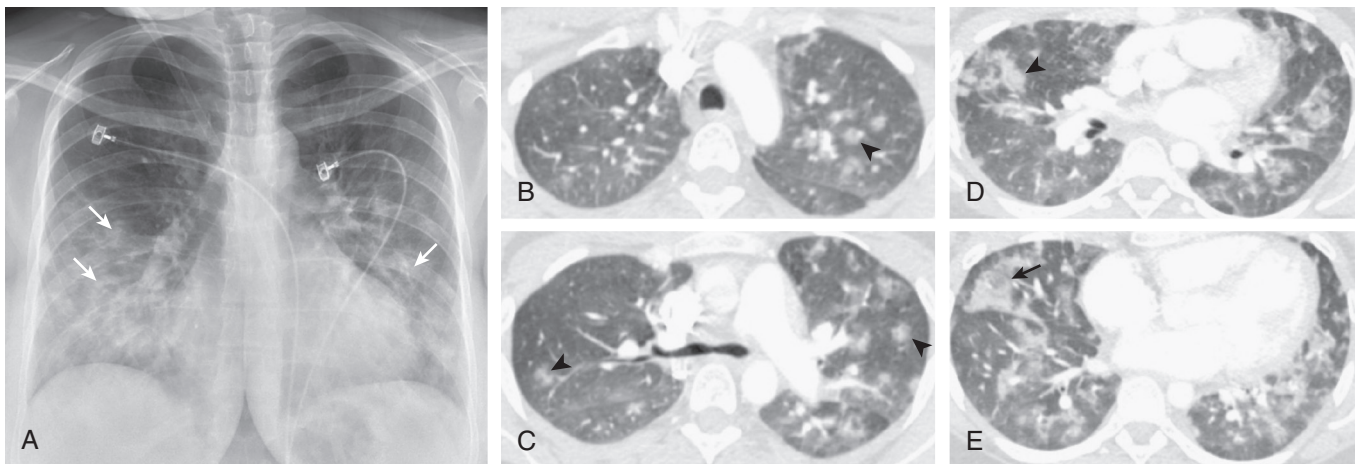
Amniotic fluid embolism. A, Frontal chest radiograph in a patient who developed shortness of breath and cardiovascular instability during delivery shows multifocal, poorly defined opacities (*arrows*) along the bronchovascular bundles, distributed in the mid and lower lungs bilaterally. B–E, Axial chest CT pulmonary angiogram obtained for pulmonary embolism evaluation, displayed in lung windows, shows multifocal nodular appearing ground-glass opacities (*arrowheads*), somewhat more confluent in the right middle lobe (*arrow*). No features to suggest increased pressure edema, such as pleural effusion or interlobular septal thickening, are present, and no pulmonary embolism was detected. The CT features are consistent with an acute lung injury pattern. (Courtesy Michael Gotway, MD.)
